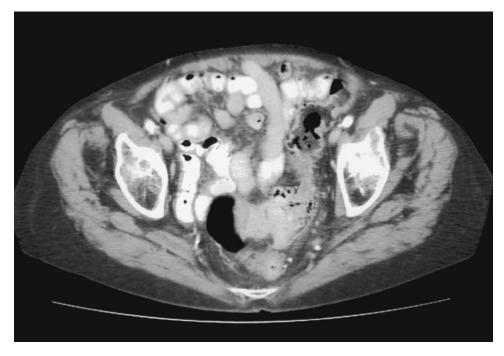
CT scan showing thickening in mid sigmoid.
